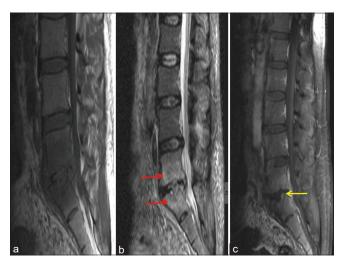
Baseline magnetic resonance imaging: (a) T1 sagittal, (b) T2 sagittal, (c) postcontrast images: The yellow arrows show mild hyperintense signal in the intervertebral disc between L5 and S1. The red arrows show marrow edema in L5 and S1 vertebral bodies. There is no enhancement of the intervertebral disc
